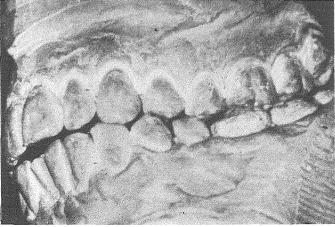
(Top, left). Roentgenograms taken 10 years after treatment. FIG. 457 (Bottom, left). The clinical appearance 10 years after treatment.
